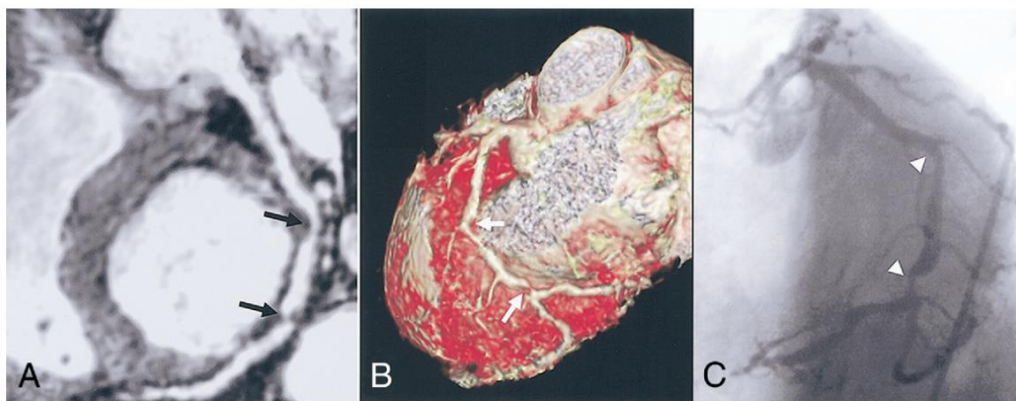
Comparison of MRA and conventional X-ray angiography⁴⁵. (A) MRA identified stenosis in a left anterior descending artery (LAD, black arrow) (B) Volume rendered view from MRA (white arrow indicating stenosis) (C) Image of the same stenosis in conventional X-ray angiographic (white arrowhead)
